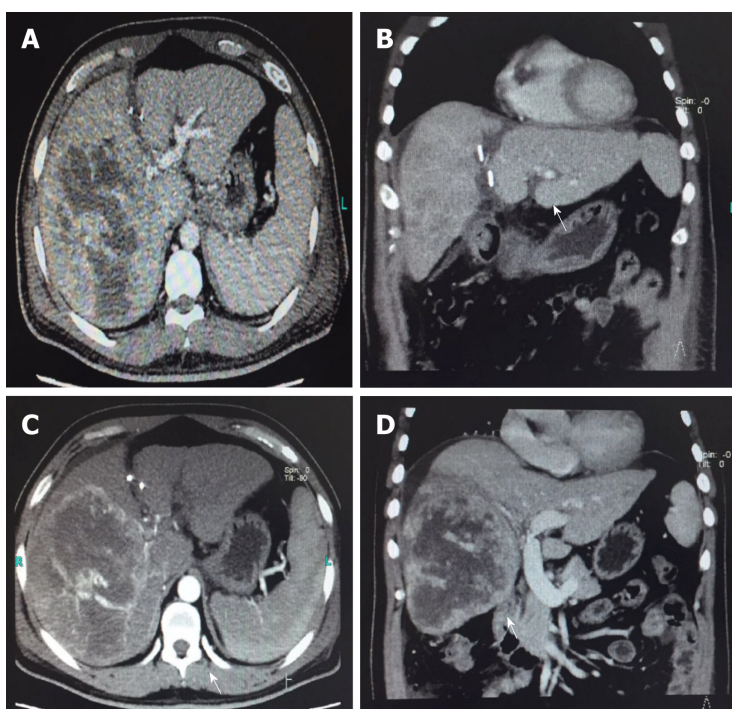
Postoperative computed tomography images. A and B: Computed tomography (CT) transverse (A) and coronal (B) images on the 9th day after operation; C and D: CT transverse (C) and coronal (D) images on the 16th day after operation.
